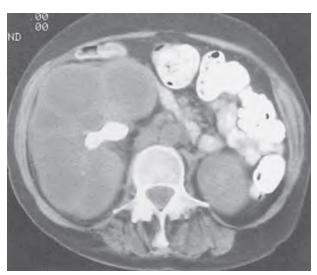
Computed tomography scan of a patient with right-sided xanthogranulomatous pyelonephritis. A huge multilobulated inflammatory mass replaces the right kidney. *Proteus mirabilis* was grown from the urine. (Courtesy Dr. L. E. Nicolle.)
